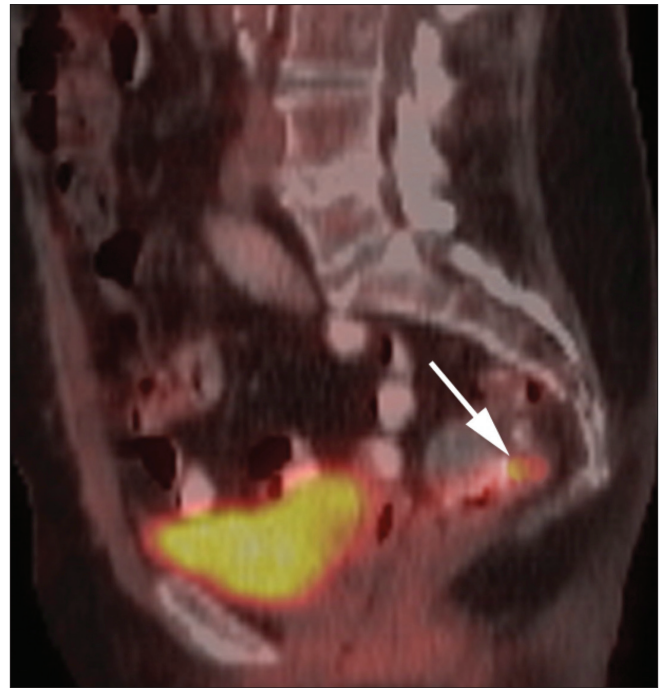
PET/CT image shows a recurrent rectal tumor as a hot spot (arrow) just anterior to the presacral fascia
